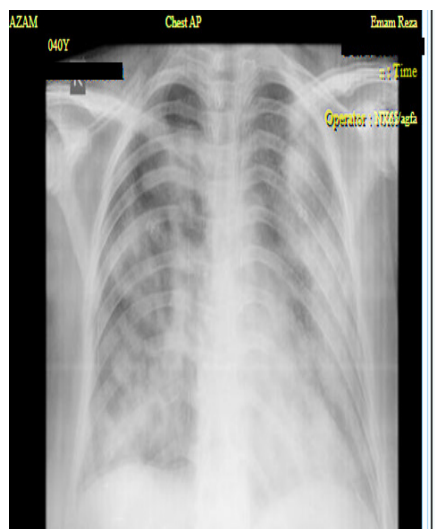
Chest x-ray showing multifocal consolidations
